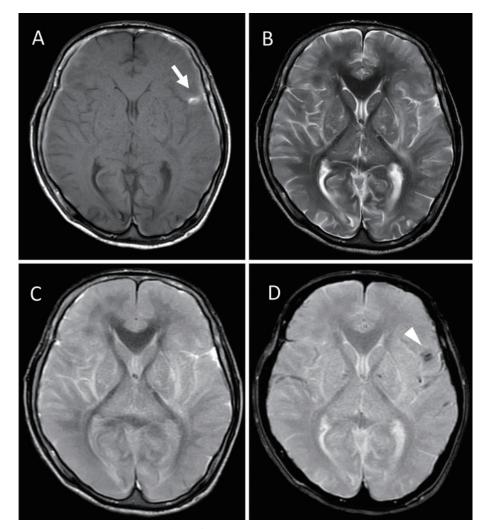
Magnetic resonance imaging obtained 26 days after the onset. Axial T1-, T2-, Fluid-attenuated inversion recovery (FLAIR), and T2*-weighted imaging (T2*-WI) at the anterior horn of the lateral ventricle showing diffuse cerebellar and cerebral edema with effacement of the sulcal spaces (A-D). T1-weighted imaging reveals a small high-intensity region in the left Sylvian fissure (arrow) (A), and axial (T2*-WI) imaging shows a hypointense region in the same region (arrowhead) (D). These findings reveal a small subarachnoid hemorrhage in the left Sylvian fissure. FLAIR image showing hyperintensity in the left Sylvian fissure and the basal cistern and sulcus (C).
